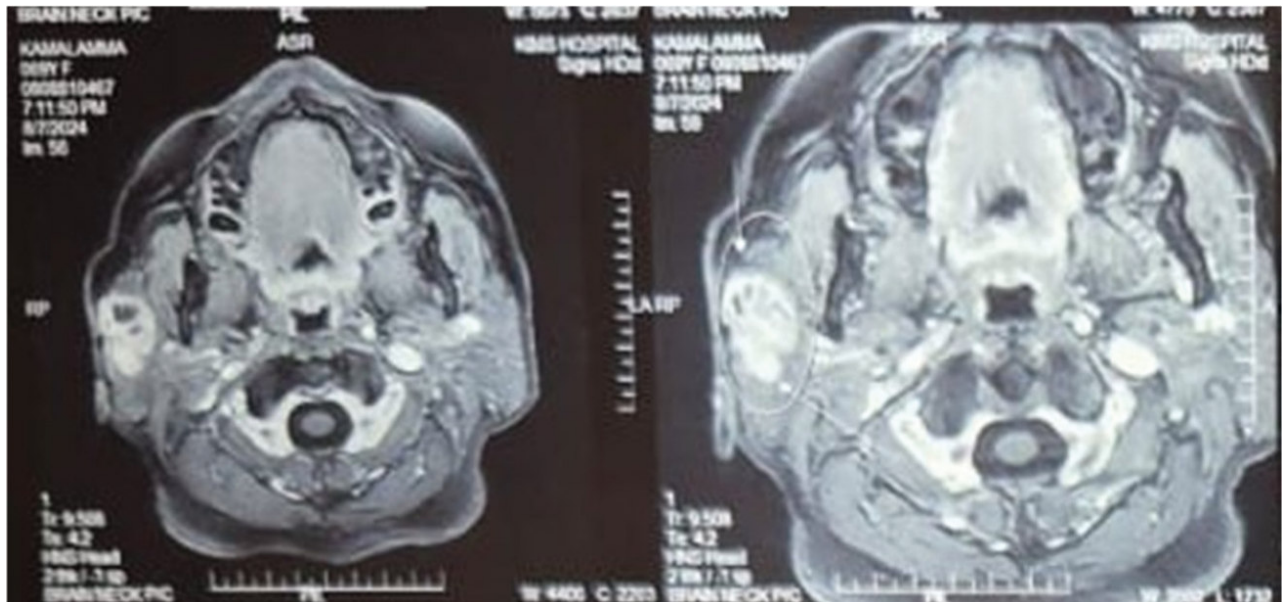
Contrast enhanced MRI of parotid swelling
